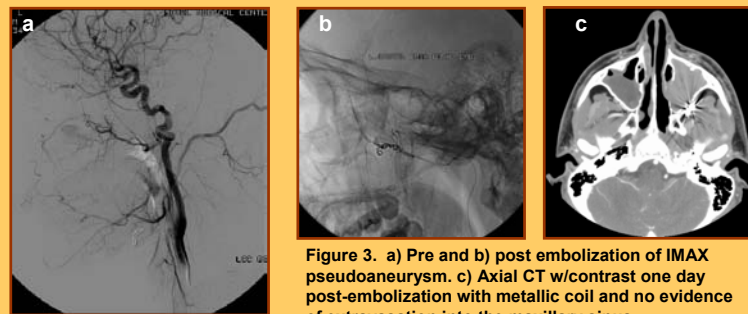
a) Pre and b) post embolization of IMAX pseudoaneurysm. c) Axial CT w/contrast one day post-embolization with metallic coil and no evidence of extravasation into the maxillary sinus.
